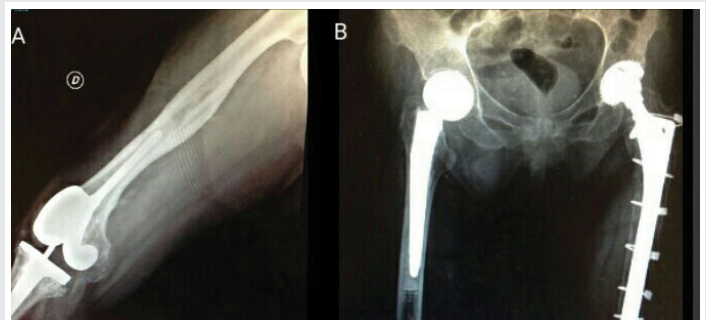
(A) Right lateral knee radiograph in a patient with PTR. (B) Anteroposterior radiograph of the pelvis and proximal femur. It is observed in primary PTC right hip and PTC left hip revision with cerclages.
